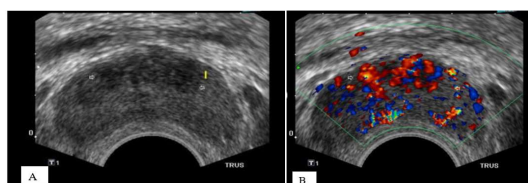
A Acute prostatitis: Transrectal ultrasound axial image showing markedly hypoechoic patches in the inner zone of prostate which show; (B) increased vascularity of colour doppler
